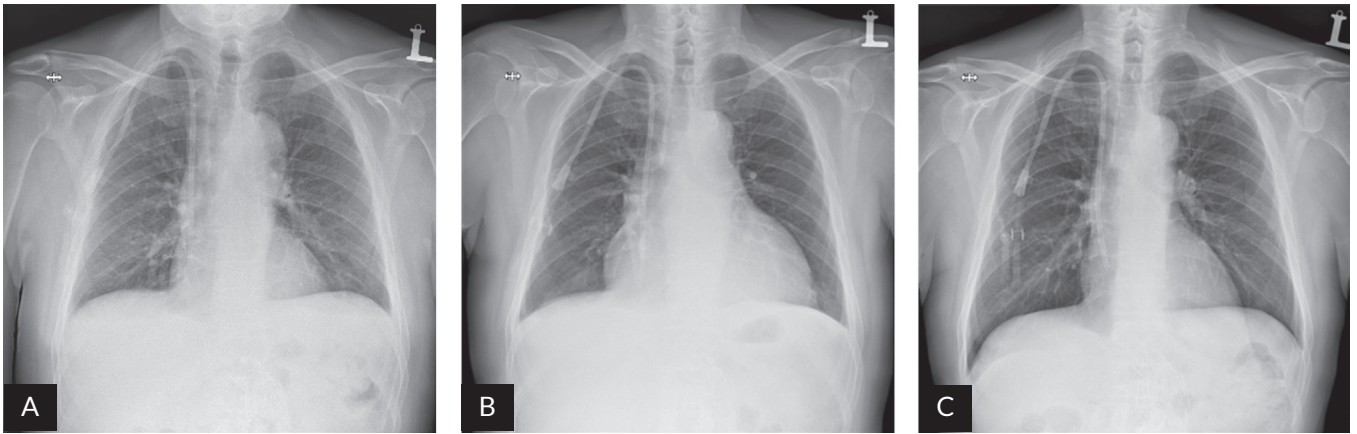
Chest X-ray: A. Before admission (March 2024); B. On admission, suspected tamponade (May 2024); C. Post-treatment follow-up X-ray (June 2024)
